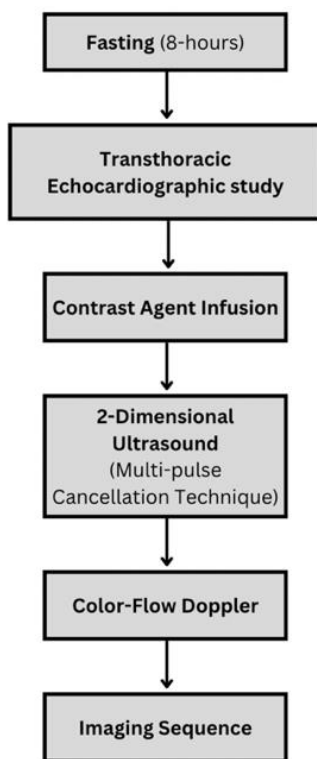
Contrast Enhanced Ultrasound Scanning Protocol. Starts with an 8-hour fasting prior to the testing day then proceeds to a transthoracic Echocardiographic study to identify the stroke volume and the potential contraindications of the contrast agent. Then, the contrast agent will be administered followed by the 2-Dimensional ultrasound using multi-pulse cancellation technique. Then, a color-flow doppler will be done to keep out of the vascular structures in order to perform the imaging sequence (3 images per pulse intervals)) with pulse intervals of 0.06, 0.25, 0.5, 1, 2, 3, 4, 5, 7, 8, and 10 seconds of the areas of interest (i.e., supraclavicular, axilla, anterior abdominal wall, and inguinal fossa). This figure was made using Canva.
